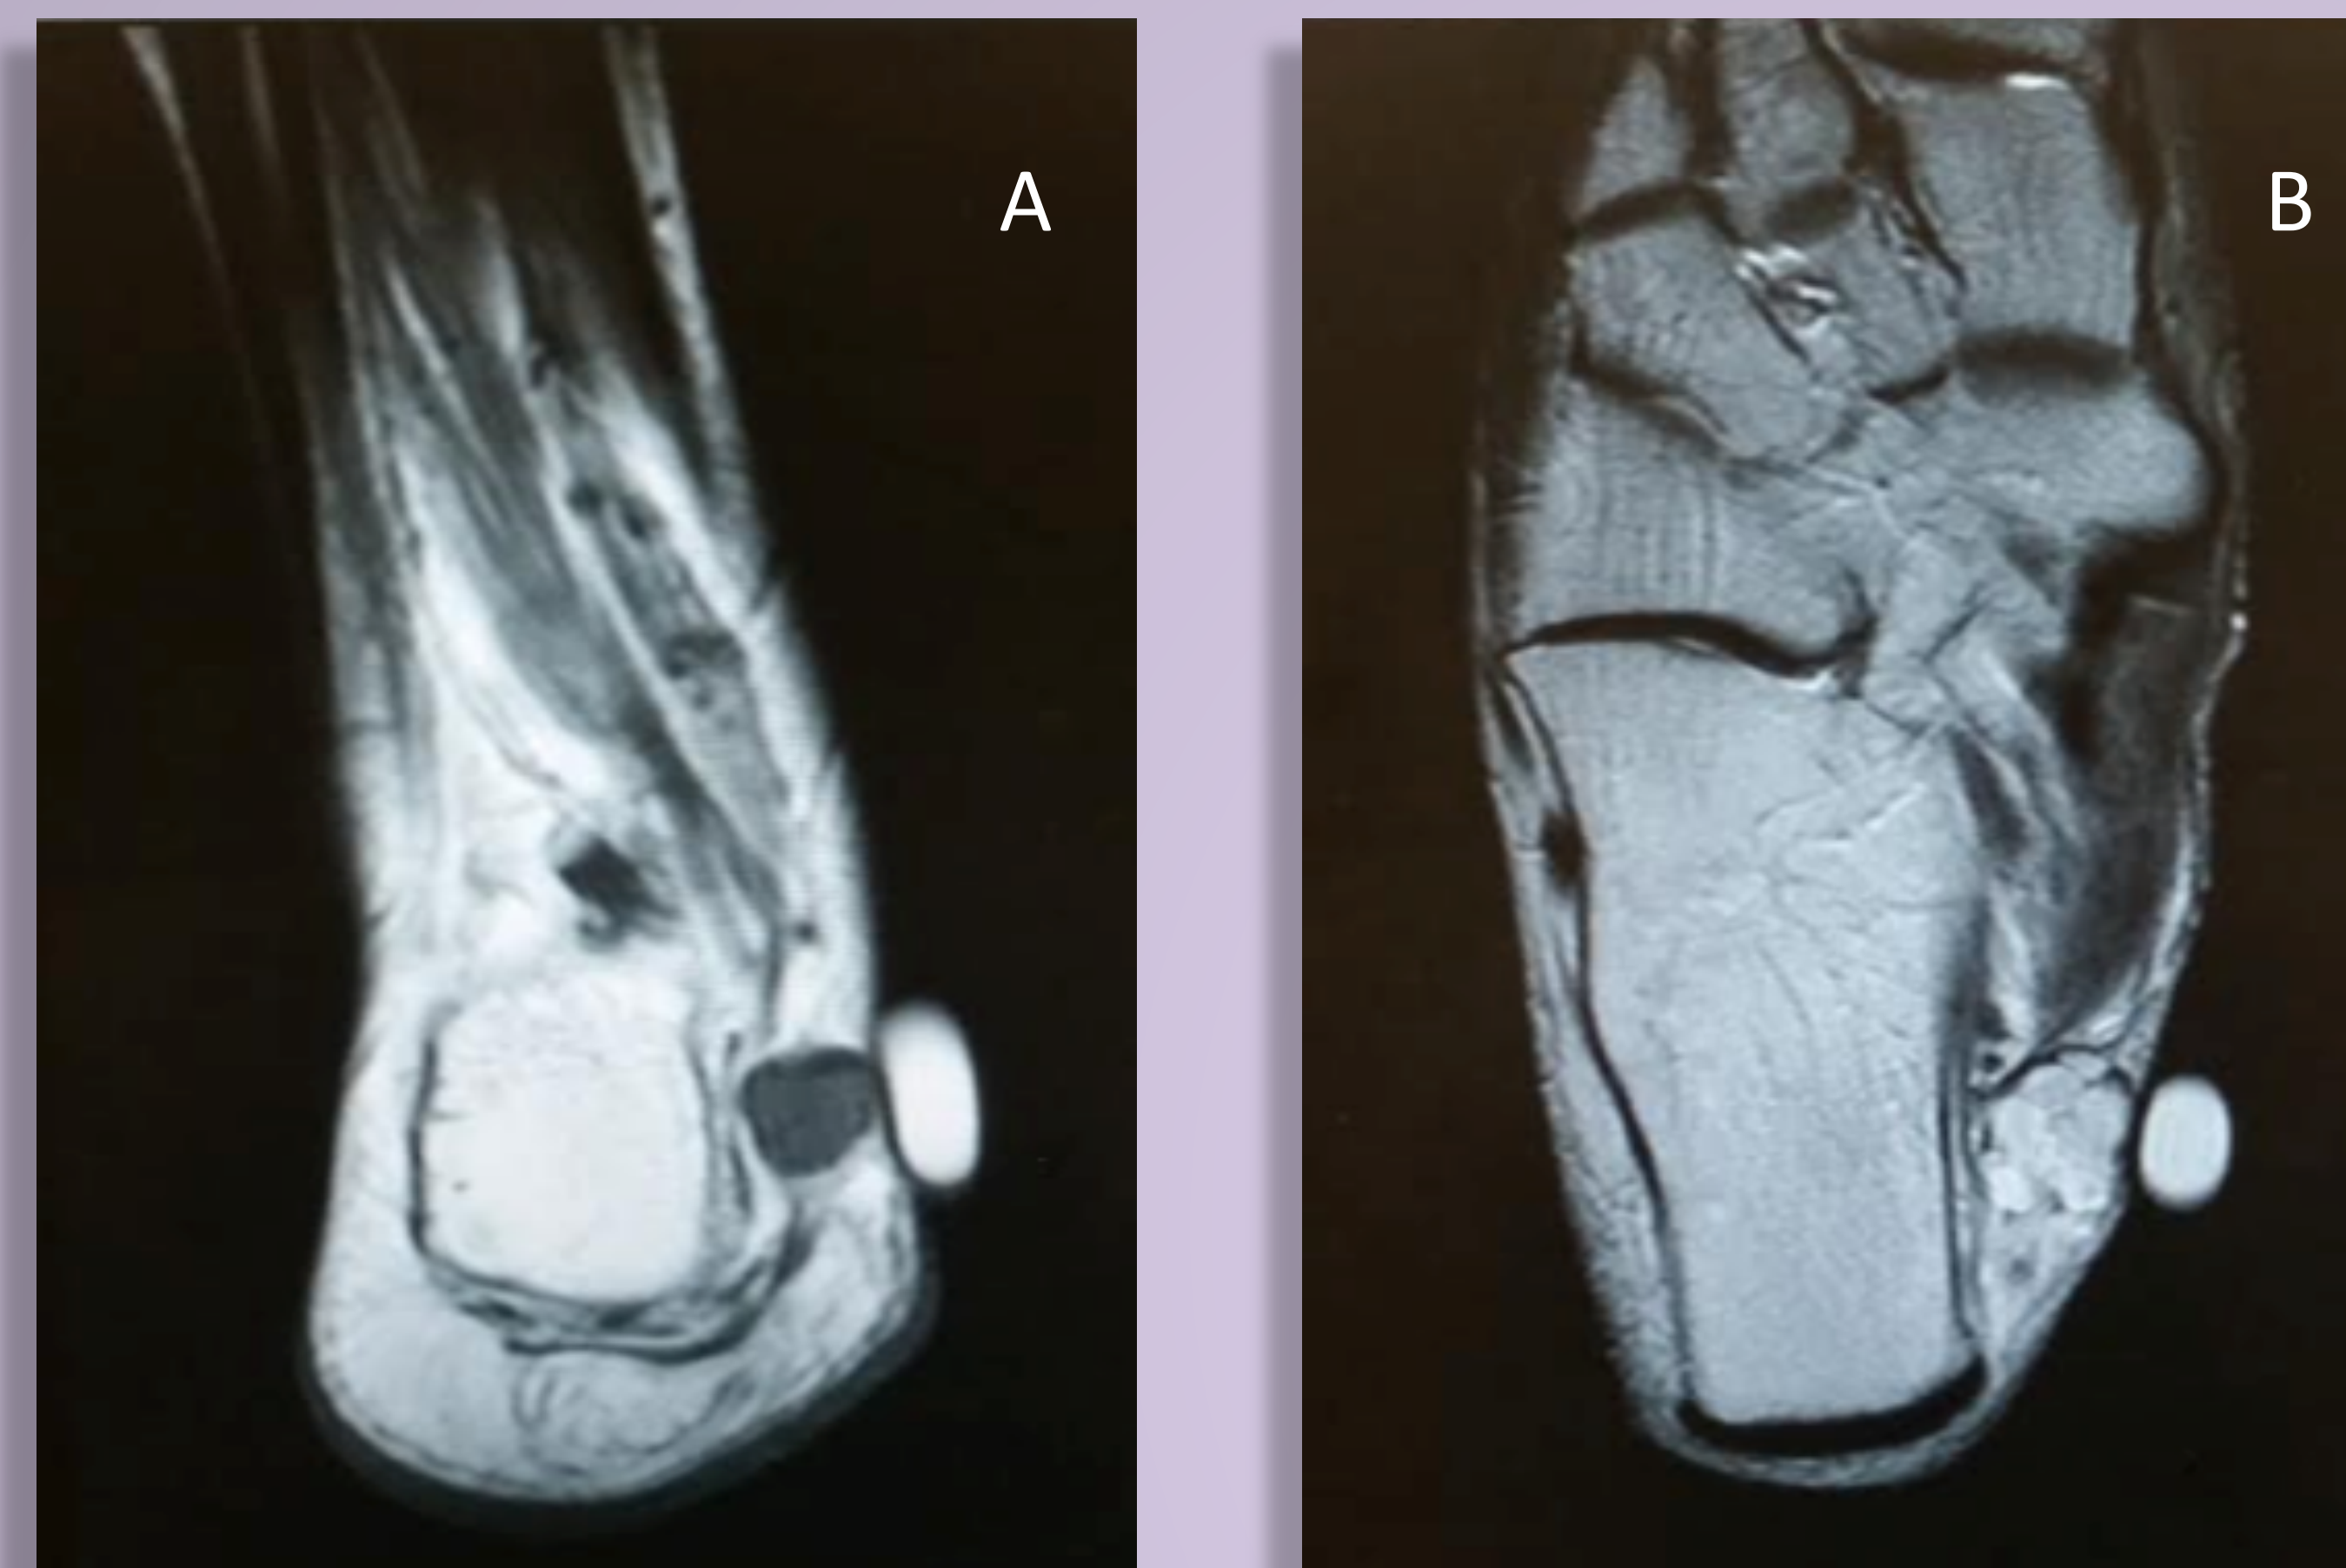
Figure (A) T1 weighted coronal MR image of schwannoma invested posterior tibial tendon. Figure (B) shows a T1 weighted axial MR image of the schwannoma.
